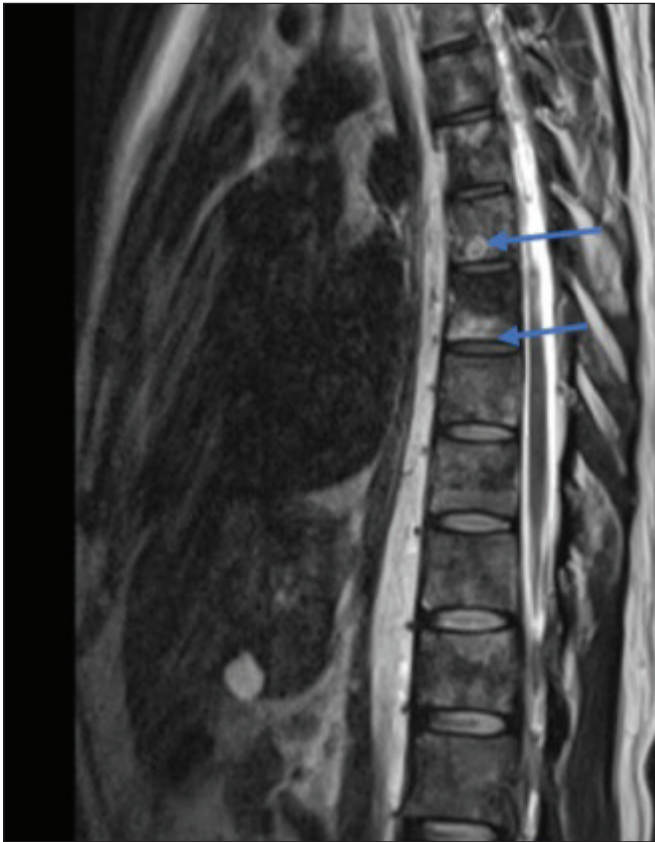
Sagittal MRI, T2-weighted, 1 month after treatment, without the presence of intramedullary images, even with the presence of a hyperintense image in vertebral bodies (blue).
